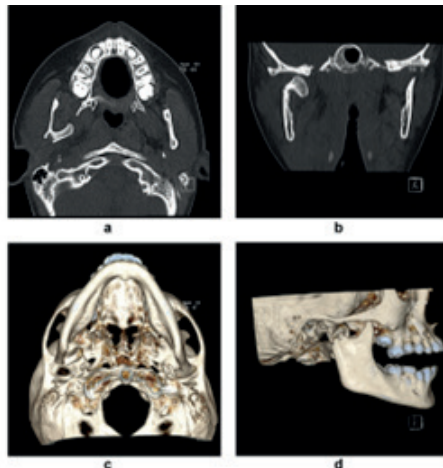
Use of CBCT in Pediatric Mandibular Fractures.
